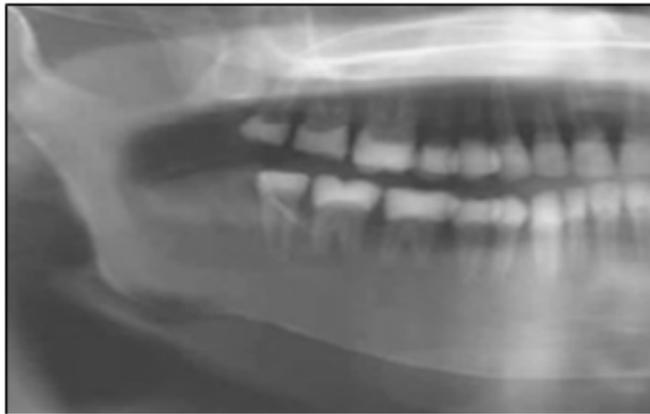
Panoramic radiograph showing underexposed film. adopted from; Iannucci and Howerton (Iannucci, 2017).
